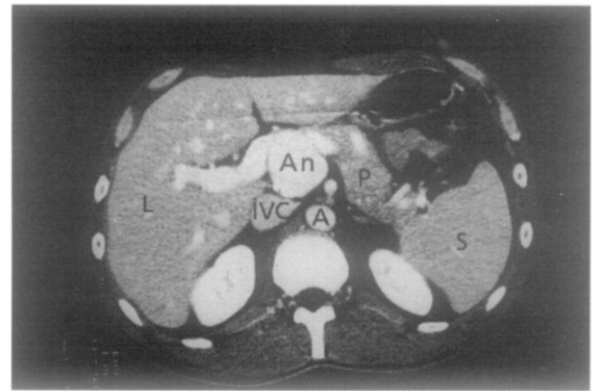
Case 1. Transverse CT scan shows aneurysm behind pancreas. *L*, Liver; *S*, spleen; *P*, pancreas; *A*, aorta; *IVC*, inferior vena cava; *An*, aneurysm.
